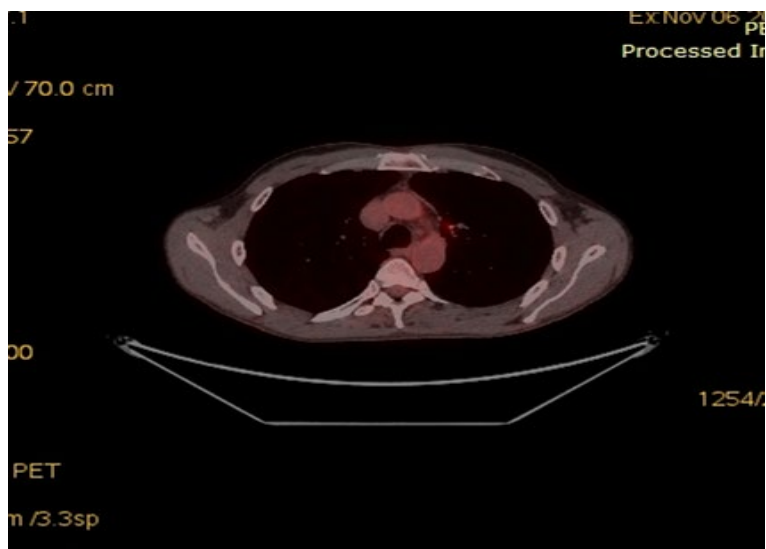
PET-CT: Complete Response
